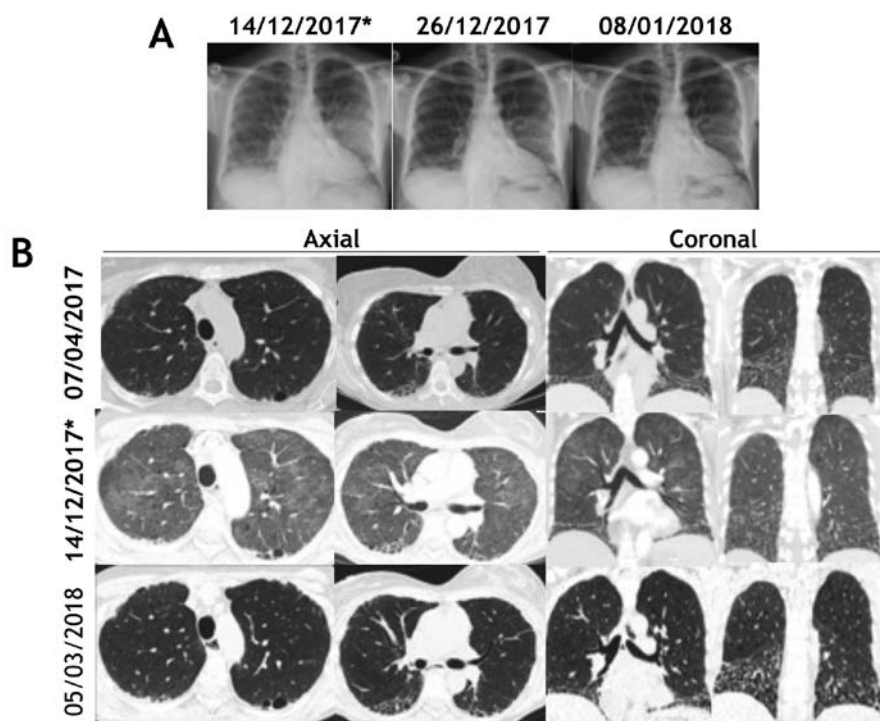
The patient experienced fatigue and self-monitoring revealed an oxygen saturation of 80% on 14 December 2017 (marked by an asterisk). The chest radiograph shows upper lobe opacities bilaterally, substantially reduced 12 and 25 days later (A); HRCT performed prior to the desaturation episode reveal basal interstitial fibrotic changes with an UIP pattern (07 April 2017). Diffuse upper lobe ground glass opacities at the time of desaturation completely resolved on subsequent imaging (B). HRCT, high-resolution computed tomography; UIP, usual interstitial pneumonia.
